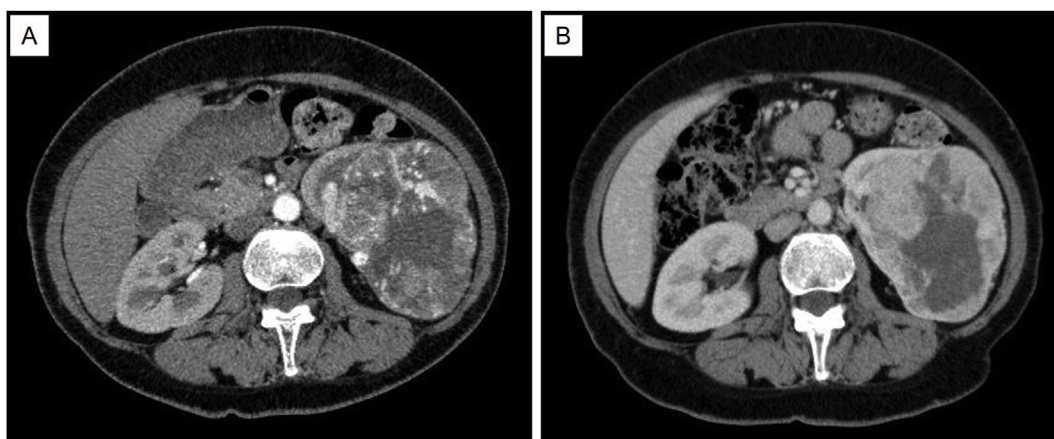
(A) Contrast-enhanced computed tomography (CT) scan shows a left renal mass at the initial diagnosis. (B) After nivolumab therapy, contrast-enhanced CT shows a renal mass with enhanced wall thickening and central necrosis.
